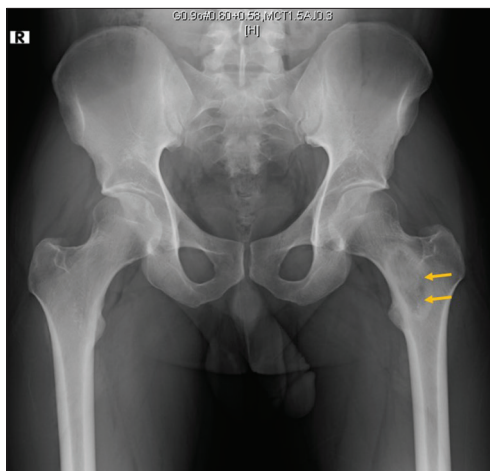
Plain radiograph of pelvis
